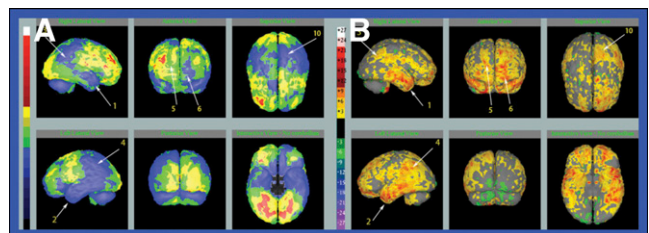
3D $^{11}\text{C-PiB}$ PET imaging (B) shows avid accumulation of tracer in amyloid plaques, contrasted with $^{18}\text{F-FDG}$ PET imaging (A).
